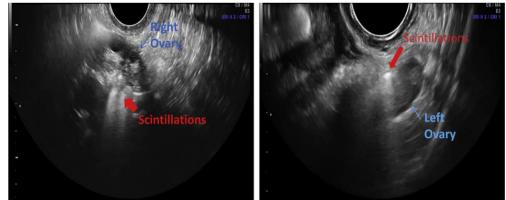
Echogenic contrast identified as scintillations (arrow) flowing over right and left ovaries during hysterosalpingo-contrast sonography [47]
